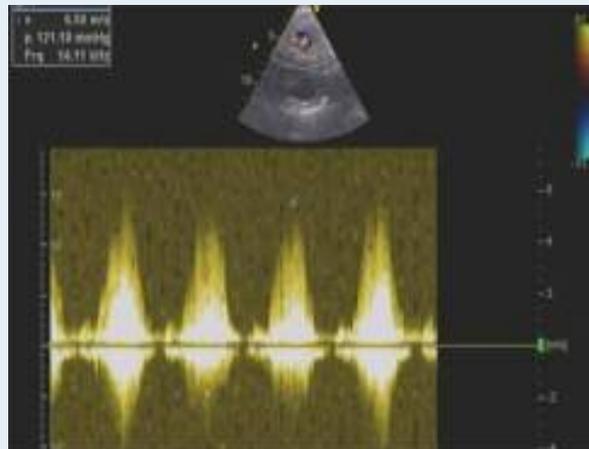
Transthoracic echocardiogram, parasternal long axis view shows Doppler peak gradient estimated at 121 mmHg in the proximal chamber under the tricuspid valve.
